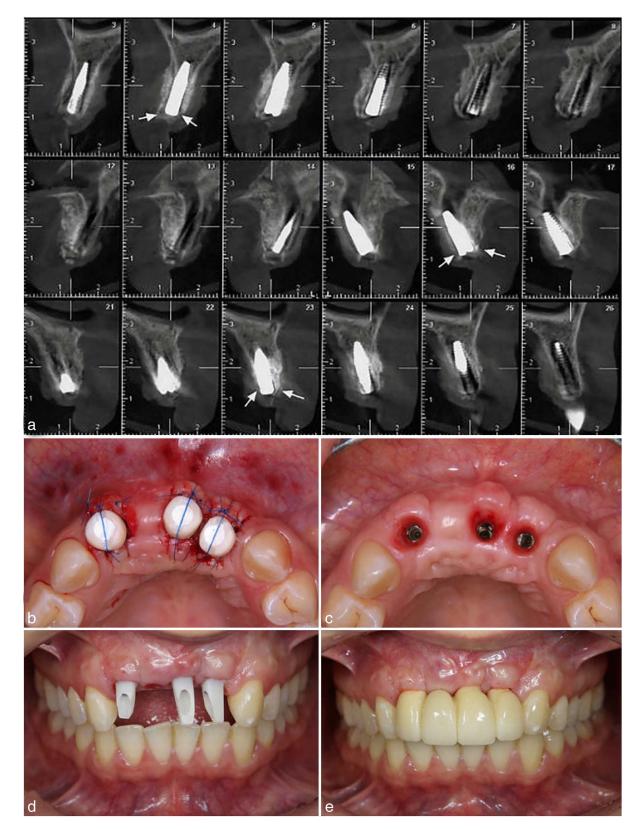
(a) Cone-beam computerized tomographic image of the case 2 weeks after implant placement. (b) Custom-made poly-methyl meta-acrylate healing caps were placed following the second-stage surgery. Coronally repositioned flaps were also performed to enhance tissue adaptation. (c) Emergence profile 6 weeks after the second-stage surgery. (d) Individually designed milled zirconia abutments were fabricated and placed. De-epithelialization of the soft tissue was also performed. (e) Final restoration was delivered.
